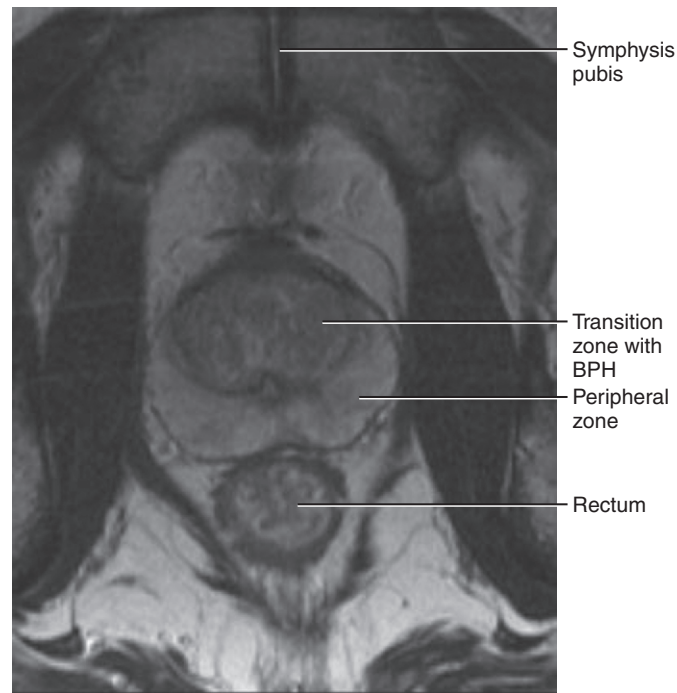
Magnetic resonance imaging (MRI) study showing an axial transverse section of the prostate and adjacent structures. (Image courtesy of Raj Paspulati, M.D.)
